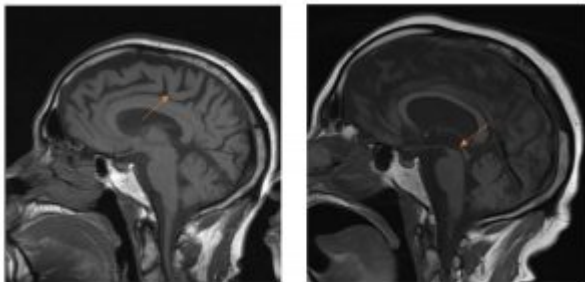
MRI T-1 weighted images, sagittal view. Left: Initial study eight years prior with greater midbrain and colliculus volume. Right: Current study demonstrating “hummingbird sign” (midbrain atrophy). [Click to enlarge](#)
